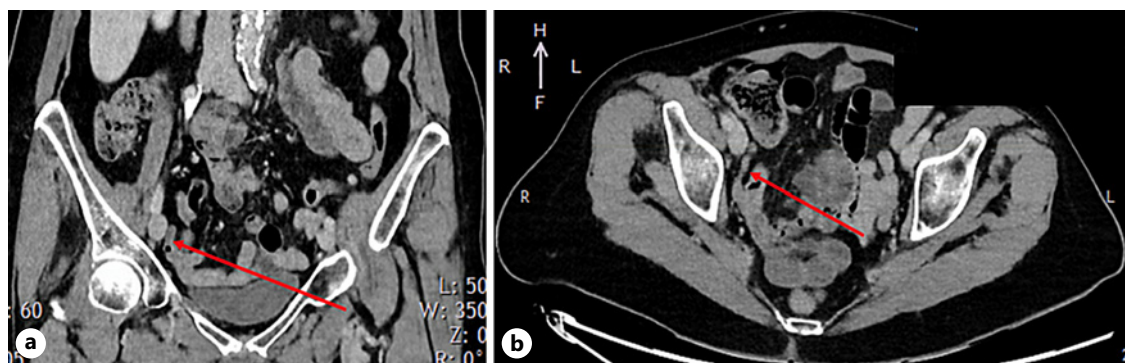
Computed tomography [coronal section (a), axial section (b)] of the abdomen showing an uninflamed appendix vermiformis (red arrow).
